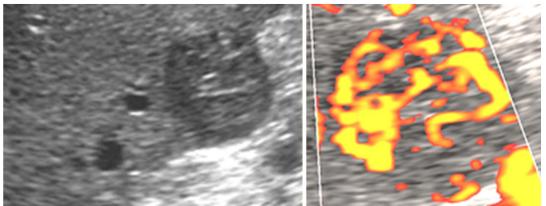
a, b Hyperperfused and with pathological vessels vascularized liver tumour (clinical HCC in chronic hepatitis C); FS right ("power mode" sonography in b)
